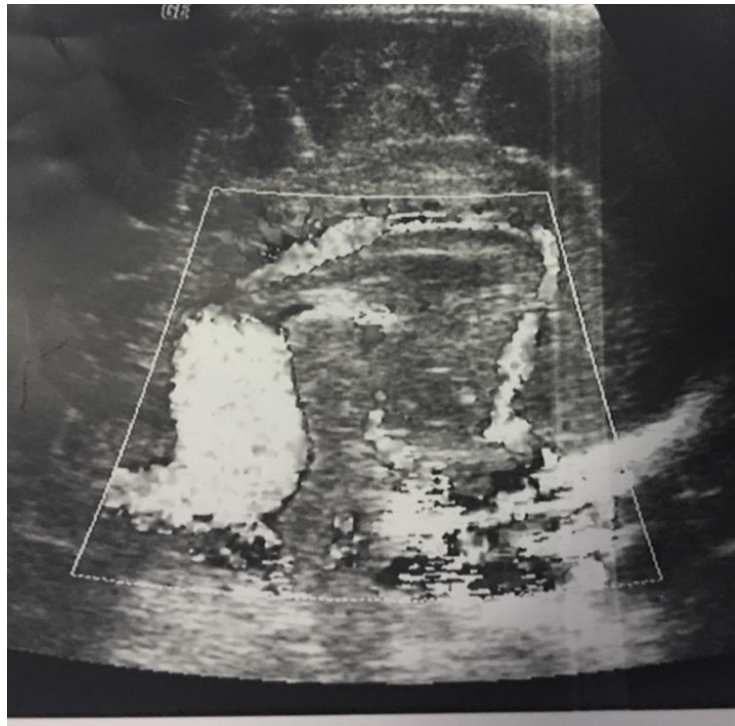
Transfontanellar ultrasound: objective an anechoic interhemispheric fusiform structure showing vascular flow on color Doppler
